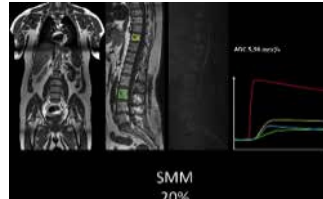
WB-MRI, DCE-MRI (+TIC) and DWI in smouldering myeloma with 20% plasma cells
